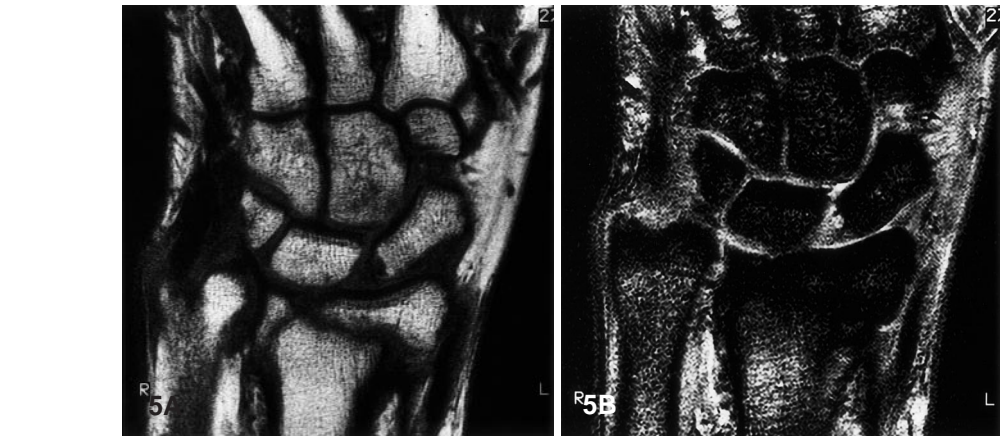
A T1-weighted spin echo coronal image (TE 15, TR 500) shows a healing impaction fracture with three well-defined fragments. B Coronal T2-weighted gradient echo (fast field echo) image (TE 30, TR 500) of same patient shows impaction and foreshortening of the distal radius. Fracture margins are obscured by susceptibility effects at trabeculae, fatty marrow and air interfaces
